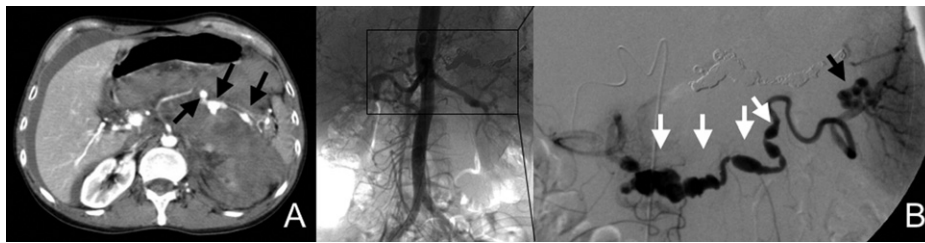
A, CT of the abdomen shows a large fluid collection in the left anterior pararenal space. Note the beaded aneurysms of the splenic artery (*arrow*). B, Selective angiography of the gastroduodenal artery. Saccular aneurysms and multiple stenotic regions are seen. There are also residual splenic artery aneurysms (*arrow*) at the distal site of coil embolization (*white arrow*).
